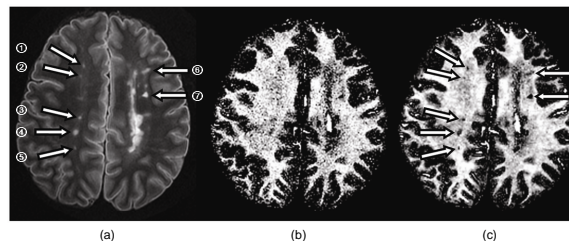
in vitro* experiments. T_2 -FLAIR image (a), MWF _{$rNNLS$} (b), MWF_{srNNLS} (c) for a fixed MS brain. Several focal MS lesions are indicated by arrows. MWF _{$rNNLS$} contains high spatial noise and the visibility of small focal lesions is low. MWF_{srNNLS} shows an improved visibility of lesions with a substantial reduction of spatial noise.
